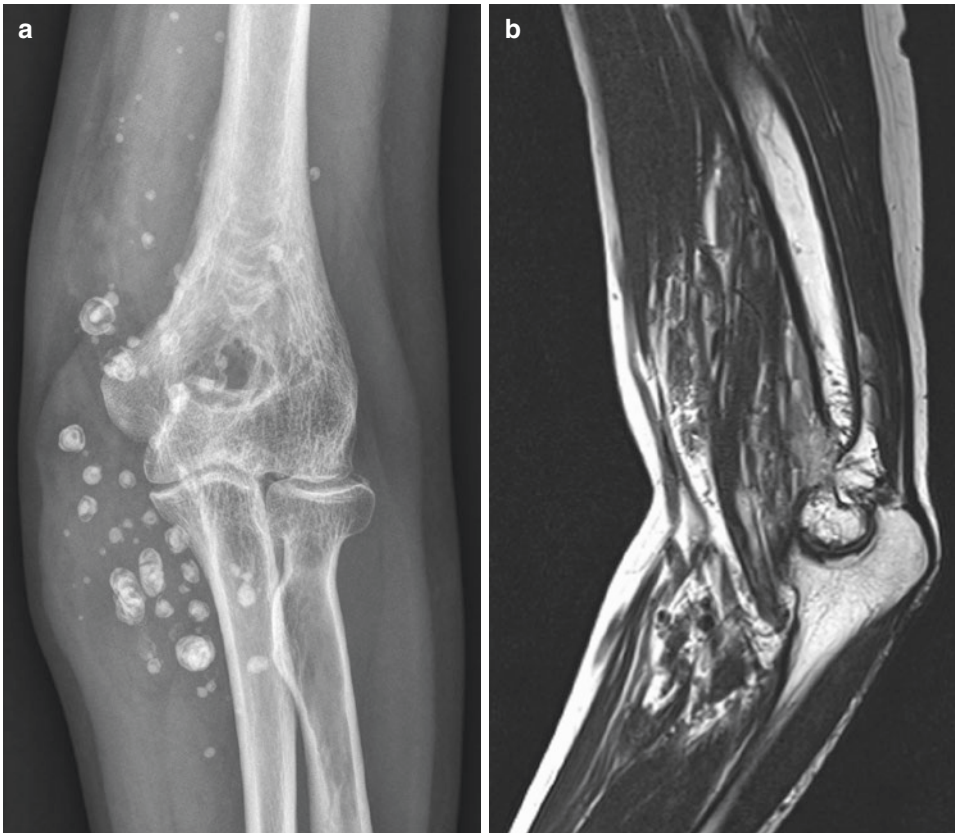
Hemangioma. AP radiograph of the left elbow (a) shows a large soft tissue mass with numerous phleboliths. Sagittal T2WI (b) shows a complex and infiltrative soft tissue mass with multiple fluid-fluid levels on the left anterior elbow
